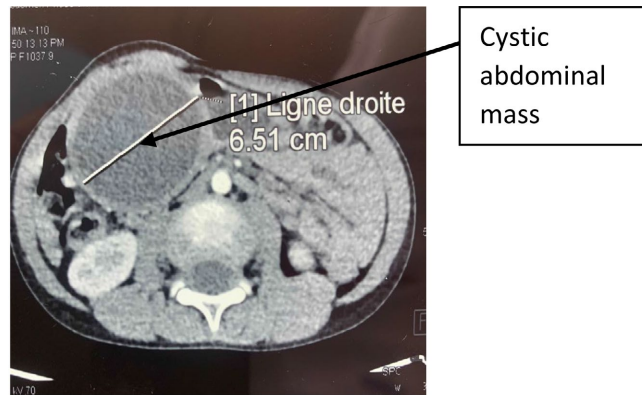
Abdominal CT scan showing cystic abdominal mass (YCH photo library).
